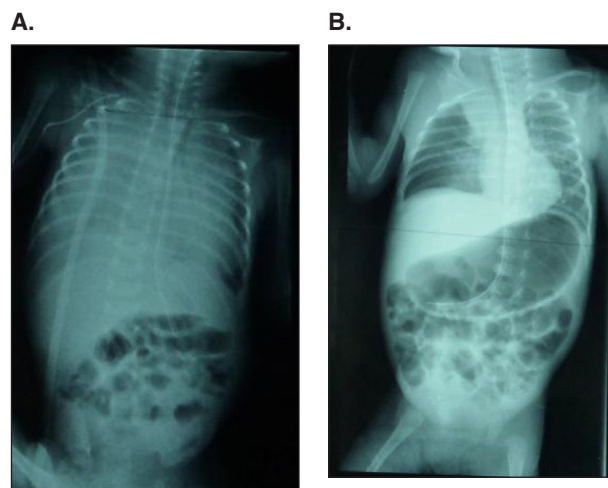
X-rays of case 2.
